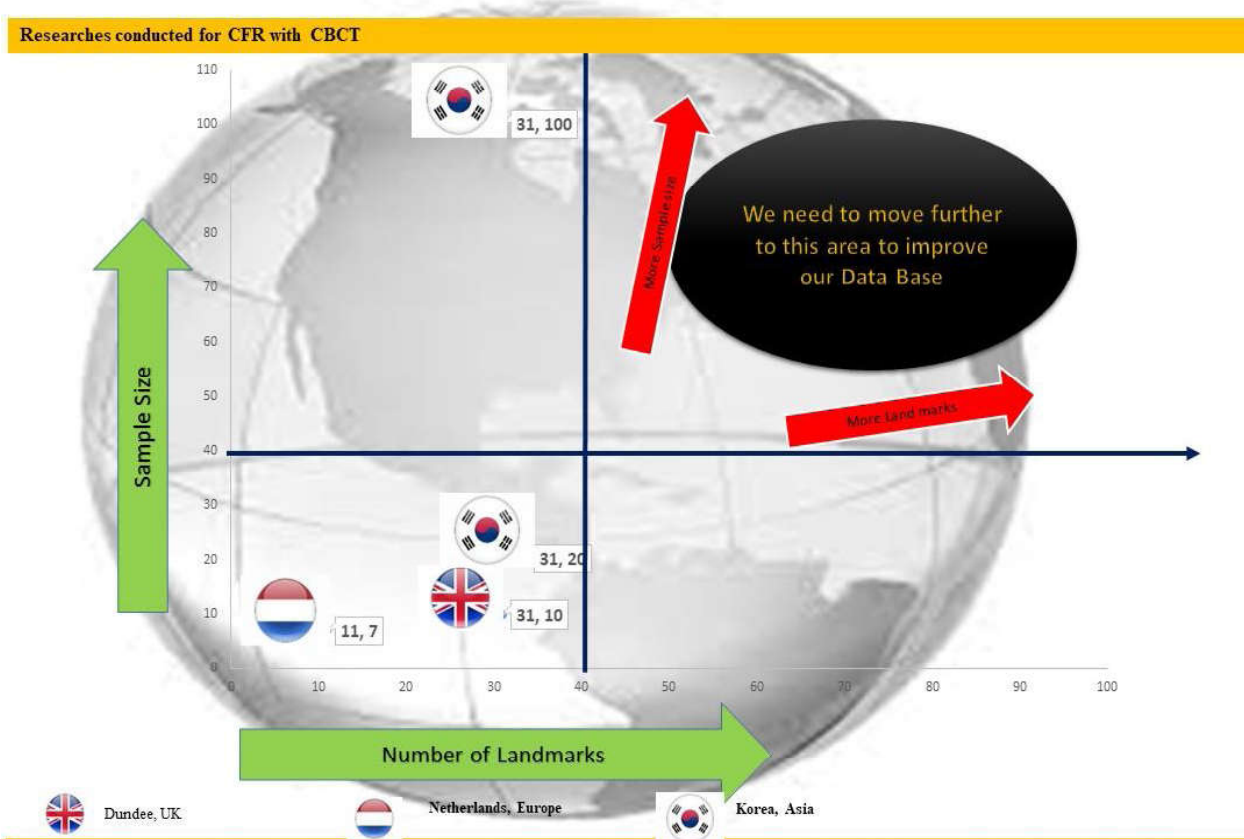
Researches conducted for CFR with CBCT
